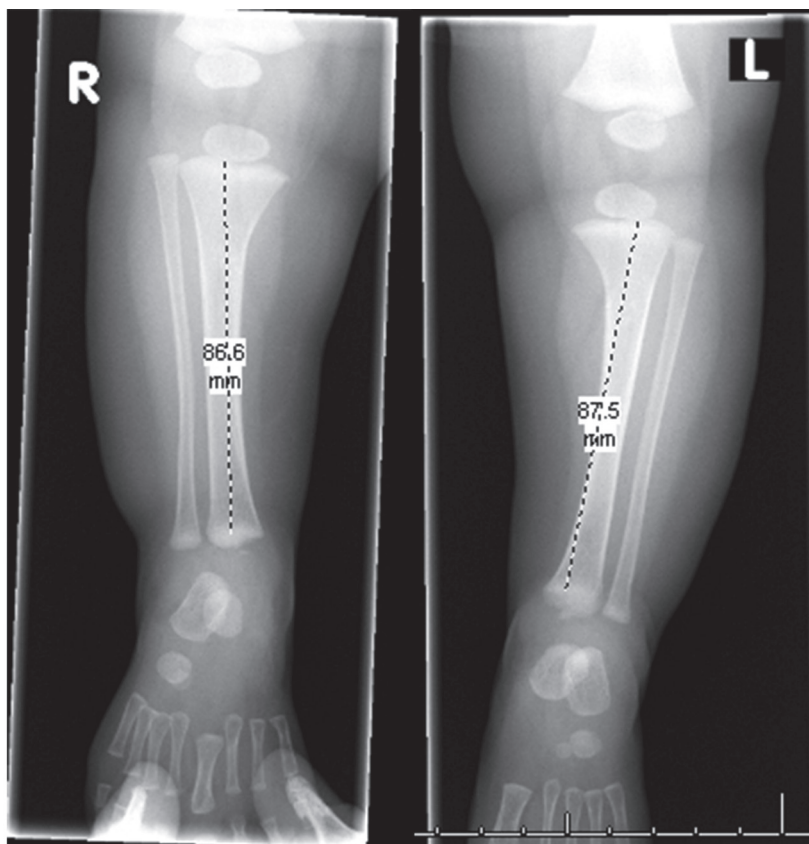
Radiograph of the left and right lower limb at the age of six months. A difference in tibial length of 0.9 cm is observed.
